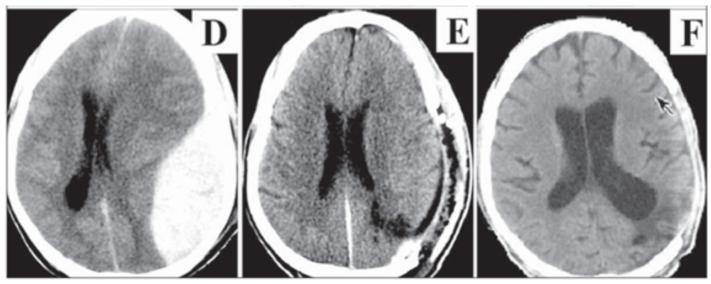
CT scans showing large parietal left extradural hematoma (A and D). B and E, immediate post op CT scan: complete evacuation of the lesion by craniectomy. C and F, delayed cerebral atrophy in the exam performed about four months after surgery.
